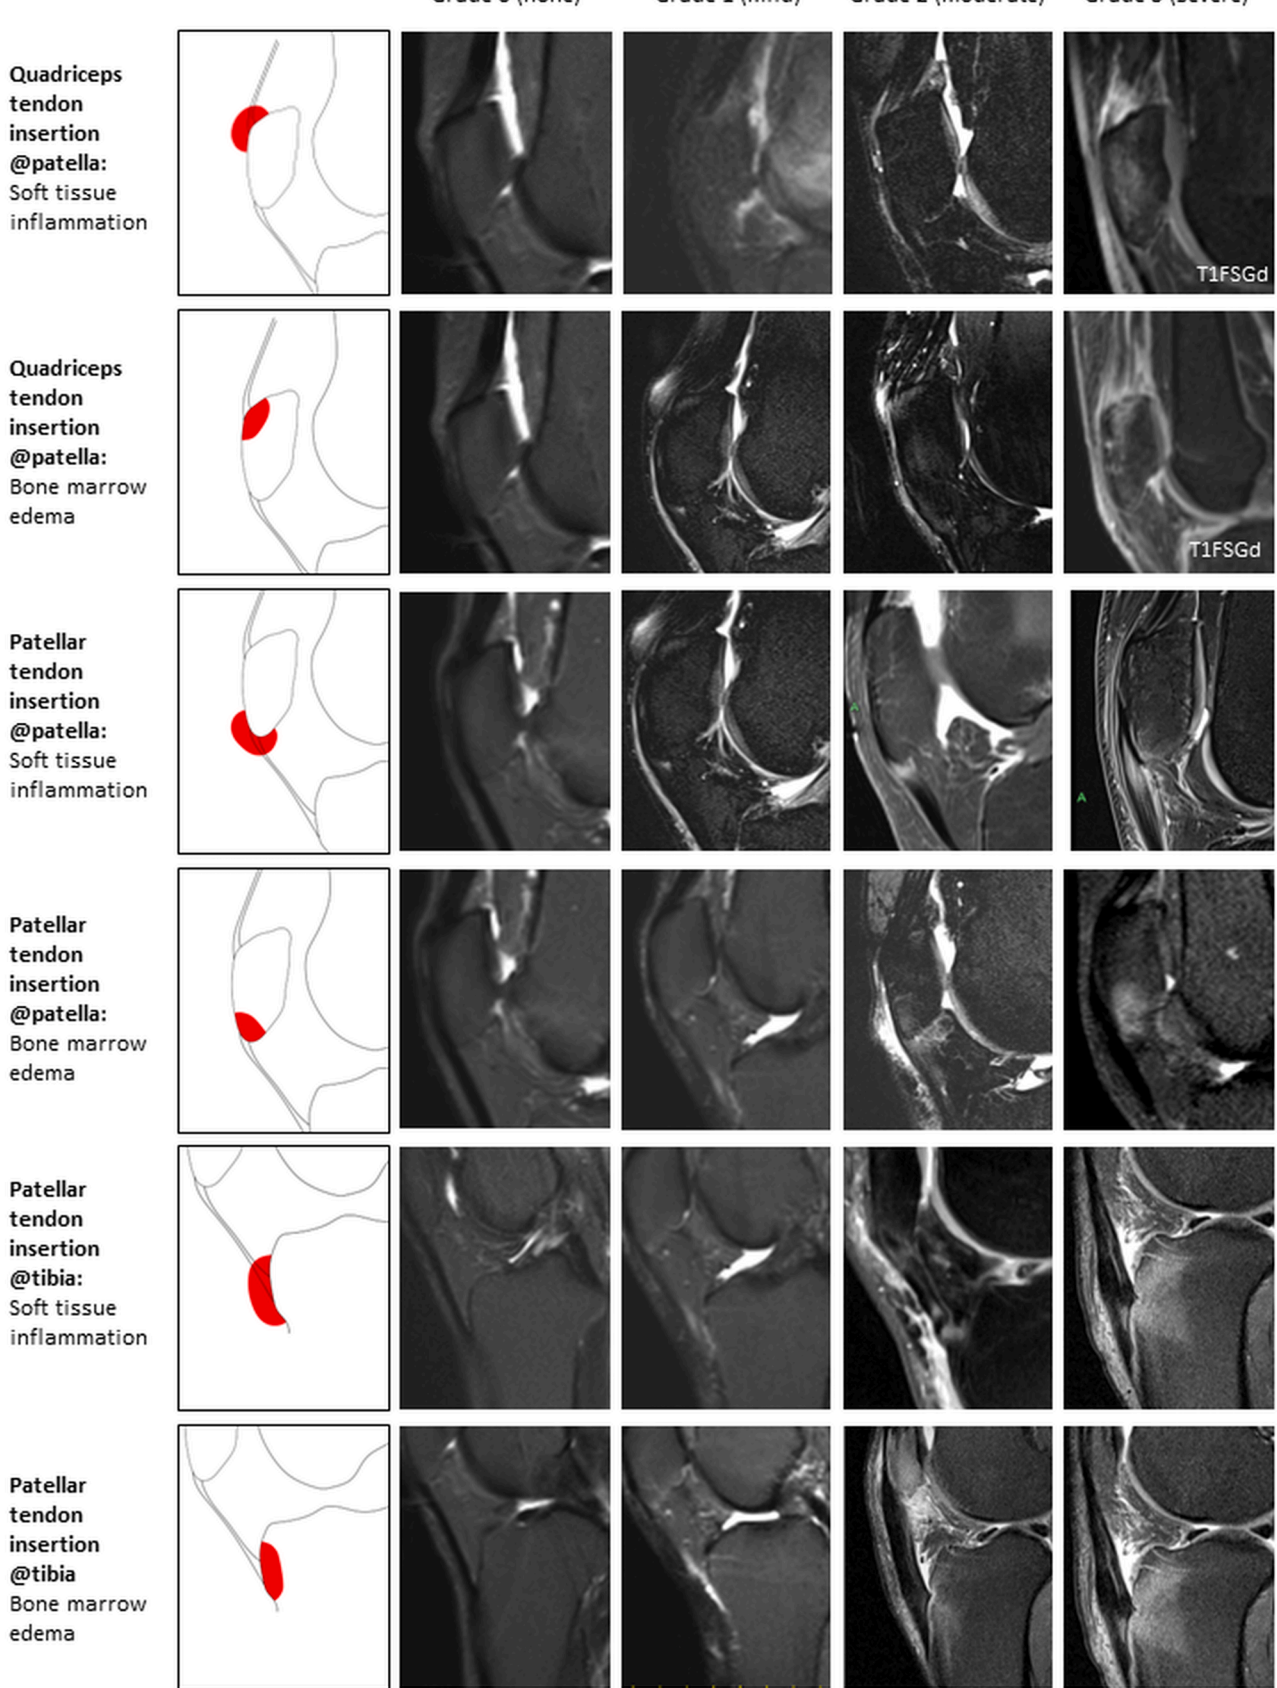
MRI-WIPE scoring system grades for enthesitis in the knee region (Part A).
